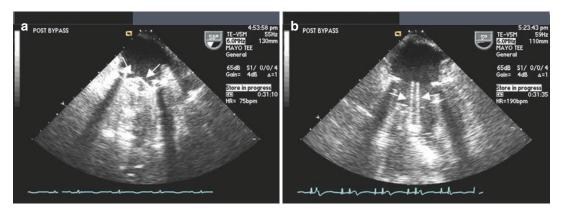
Transesophageal (TEE) view of a normal mitral bileaflet disc prosthesis in the mitral position (MVR). The arrows show a normal closed position (Panel a) and open position (Panel b)
